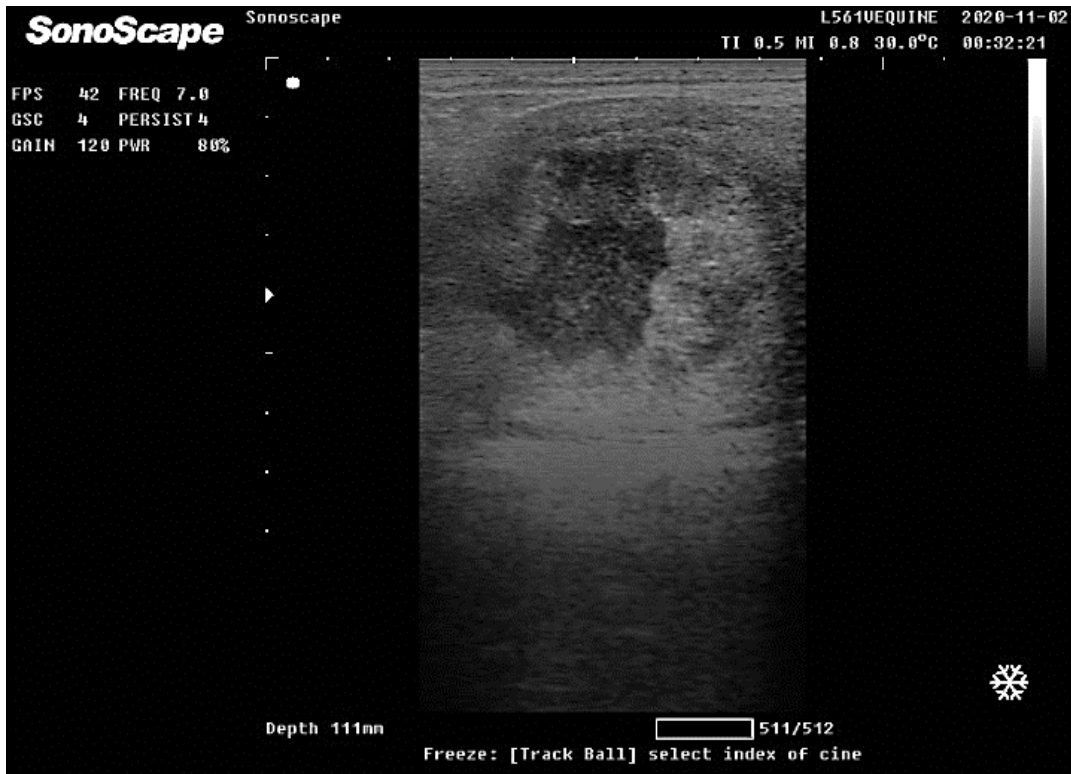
Ultrasonographic image of horn (CS) of a mare with endometritis. The lumen contains a moderate amount of exudate, and the endometrial folds bulged into the lumen.
